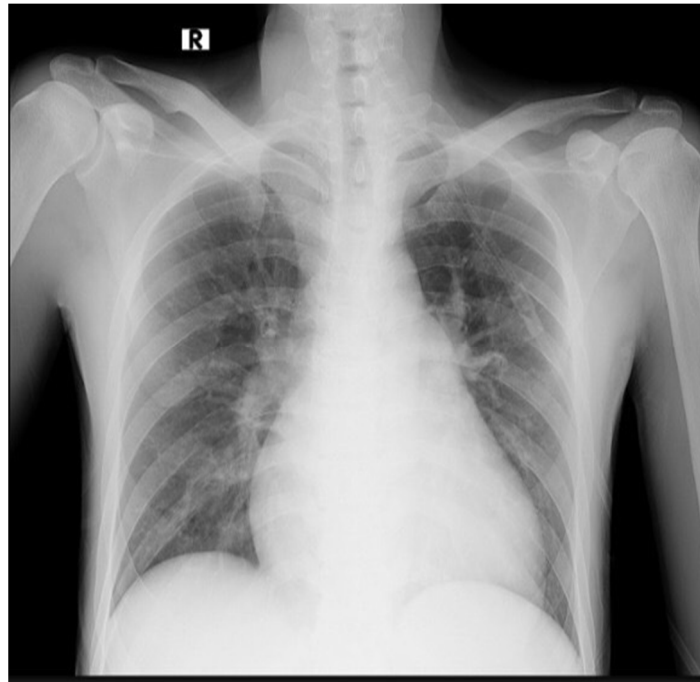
Chest x-ray at admission showing cardiomegaly with CTR 63%.
